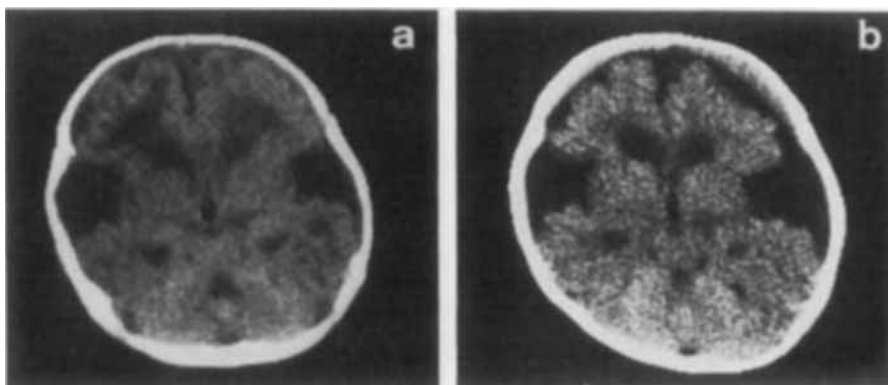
Brain CT of Case 4 at (a) 4 weeks and (b) 4 months of age.
